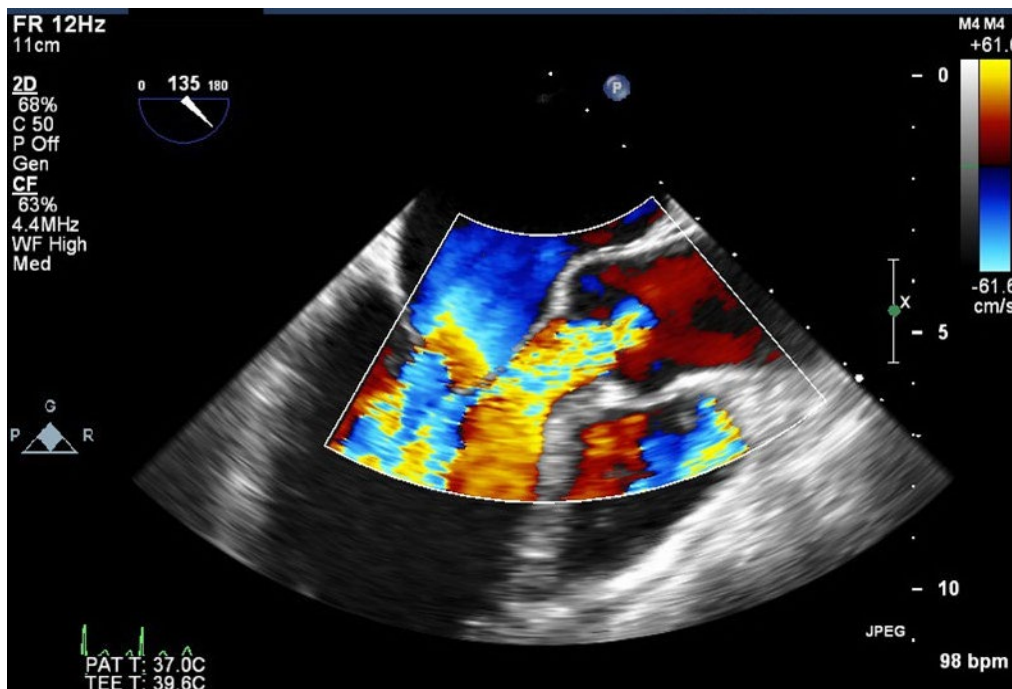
Measurement of Vena Contracta in parasternal long axis view. Source: Adapted from Smer et al. 2020.^[247]
